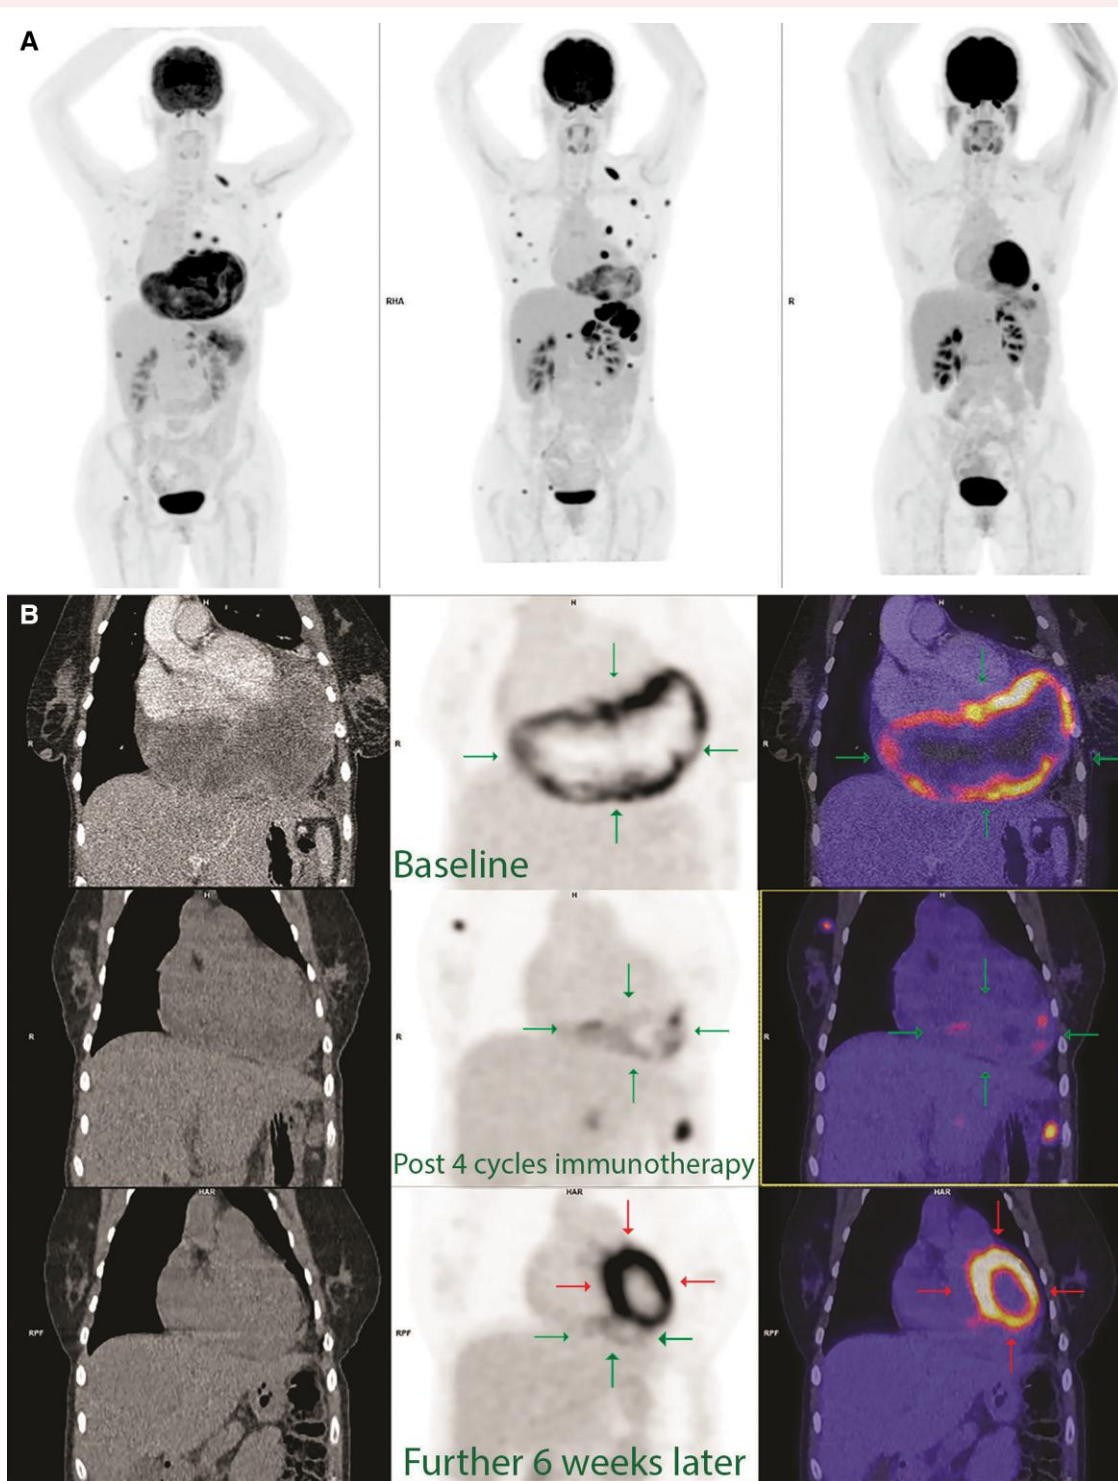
(A) Three-time-point whole-body positron emission tomography images at baseline, post-four cycles of induction immunotherapy and 6 weeks later (from left to right). (B) Three-time-point positron emission tomography–computed tomography images showing the large fluorodeoxyglucose cardiac mass (marked with green arrows) at baseline (top row), significantly improved following four cycles of induction immunotherapy (middle row), and almost completely resolved 6 weeks later (bottom row). Note the concentric normal physiologic left ventricular cardiac fluorodeoxyglucose uptake in the most recent scan (bottom row, marked with red arrows).
